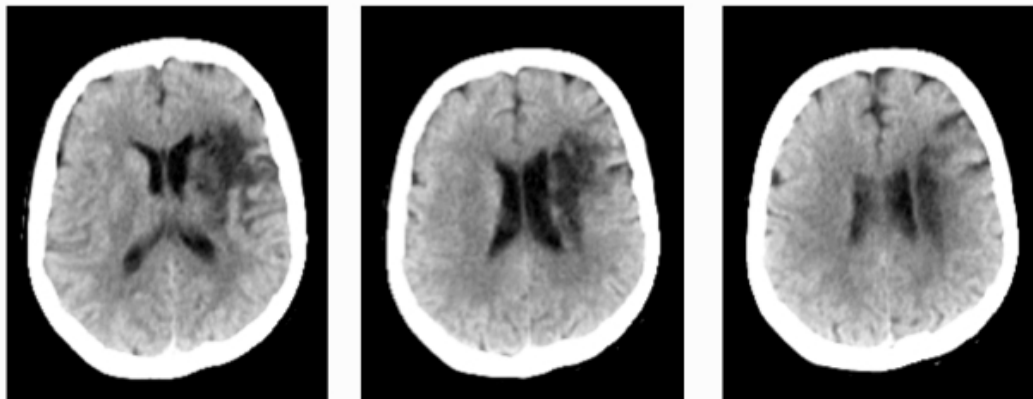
Computed tomography (CT) axial slices showing an established stroke lesion as a dark area of cerebromalacea and tissue shrinkage.
